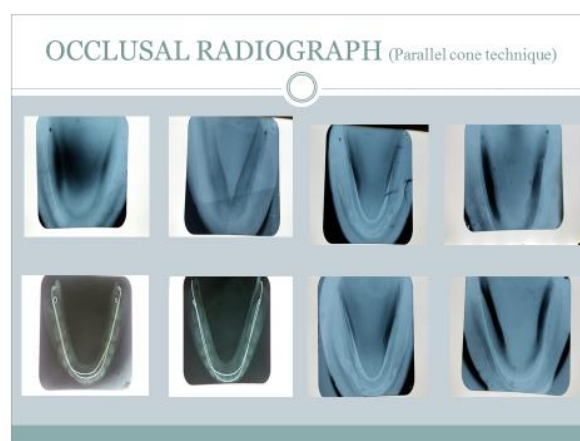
Occlusal radiographs (Parallel cone technique) used for the measurement of the shifts in lingual zones in relation to alveolar crests.
